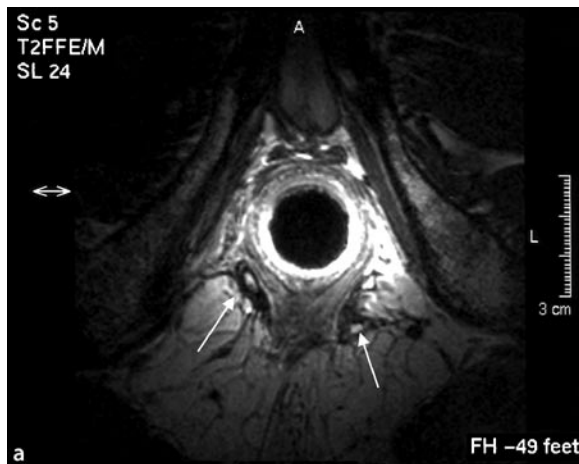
a Axial T2-weighted turbo spin-echo with endoanal coil shows two tracks outside the external anal sphincter (*arrows*). b At a more proximal level these two tracks pass through the external anal sphincter. At this level both tracks connect in a horseshoe-like fashion in the intersphincteric plane (*arrows*)
